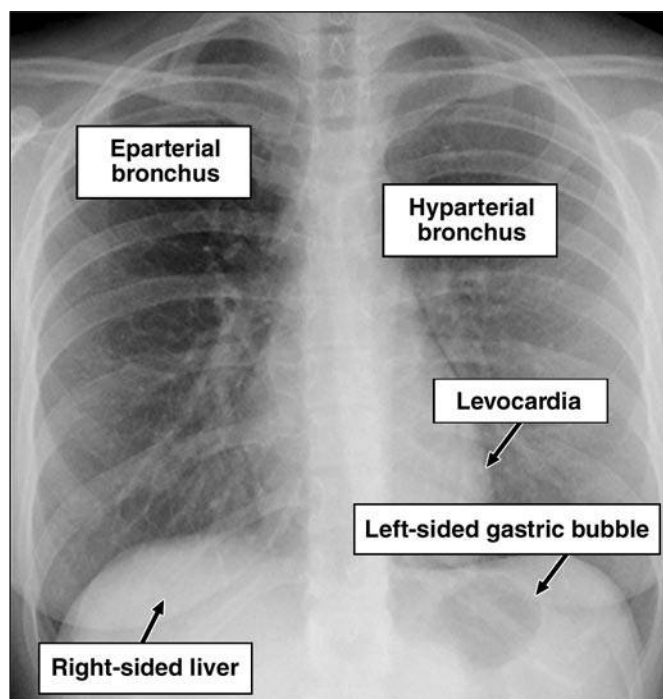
Posteroanterior chest radiograph in 27-year-old woman with situs solitus totalis. This is normal orientation. Incidence of congenital heart disease is 0.8%.
